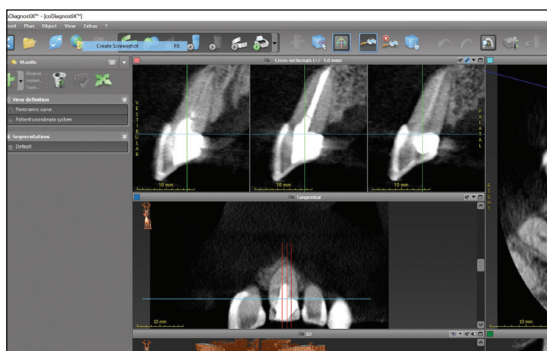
A CBCT showing the extent of the Class II external cervical resorption.
